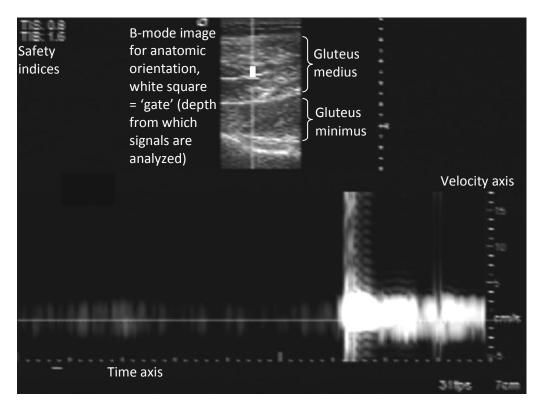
Pulsed-Wave Doppler, spectral display of an isometric gluteus medius activity in 40% MVIC.
